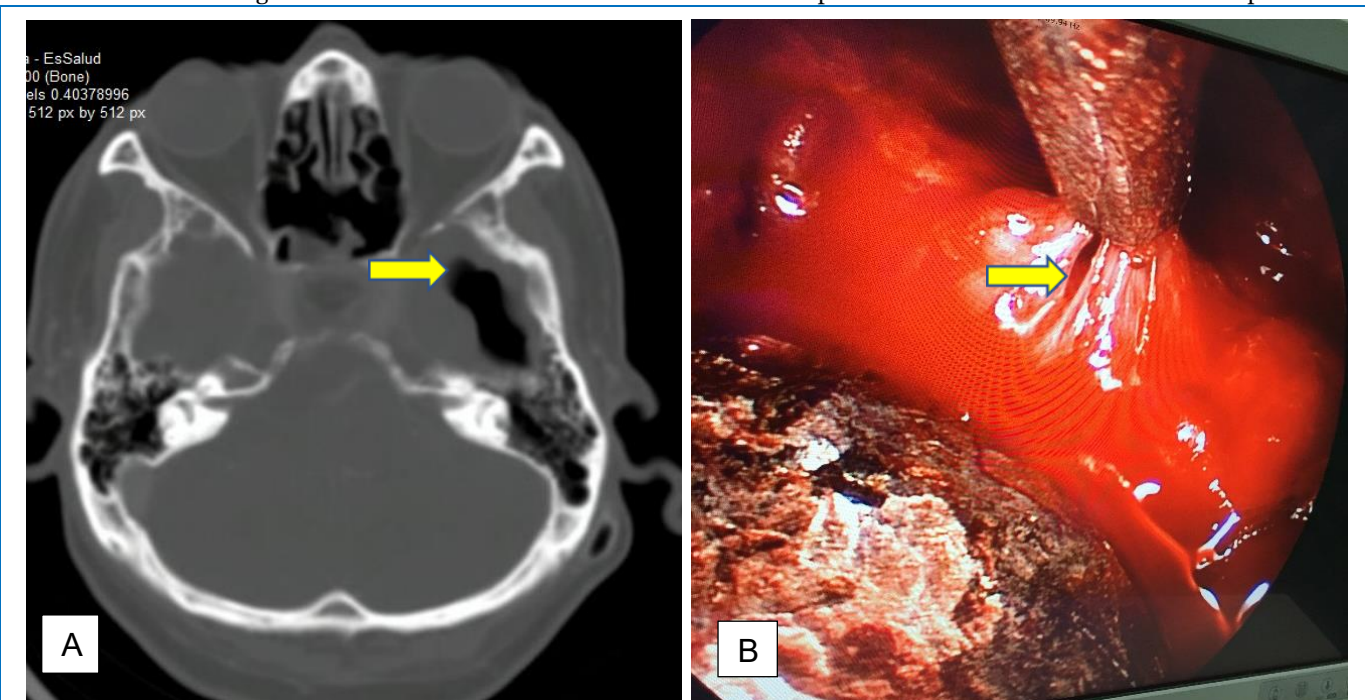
(A) Brain CT in bone window (axial view) showing evidence of bone defect in the anterior wall of the sphenoid sinus. (B) Transnasal Endoscopic Approach where an output of cysticercus cysts through bone defect is showed.
